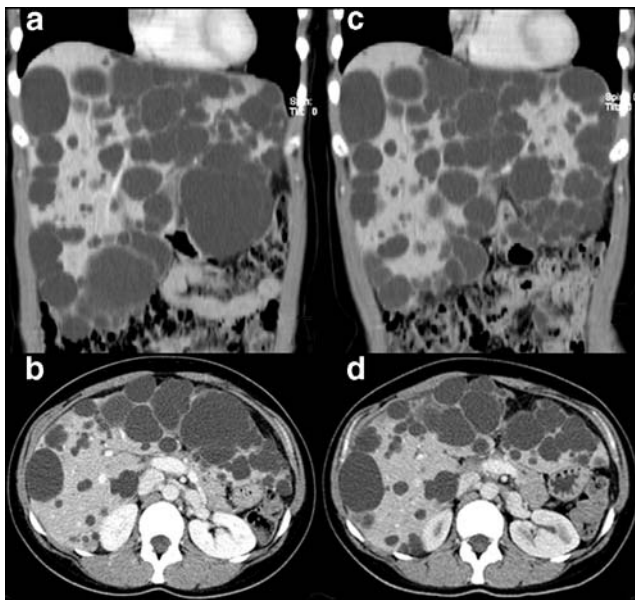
Sagittal and transversal CT slices of patient 8. a and b are preoperative, c and d are postoperative.
